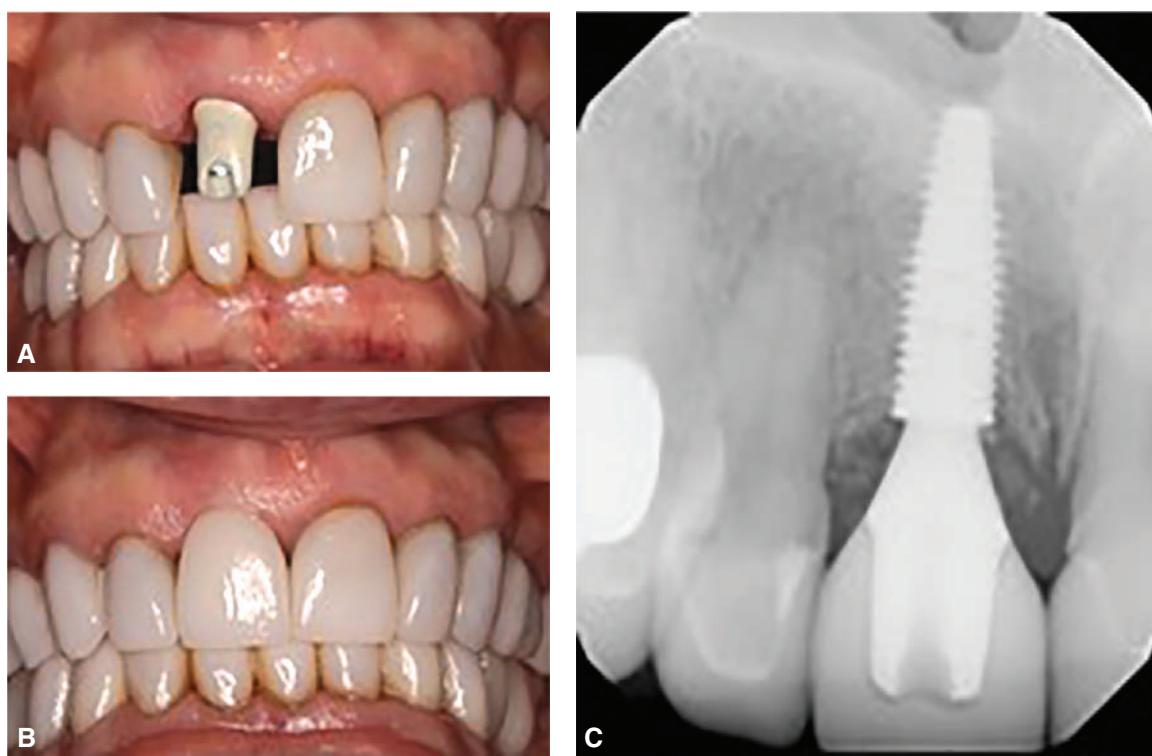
(A) Opaqued titanium abutment. (B) Zirconia crown on the opaqued abutment. (C) Periapical radiograph.
